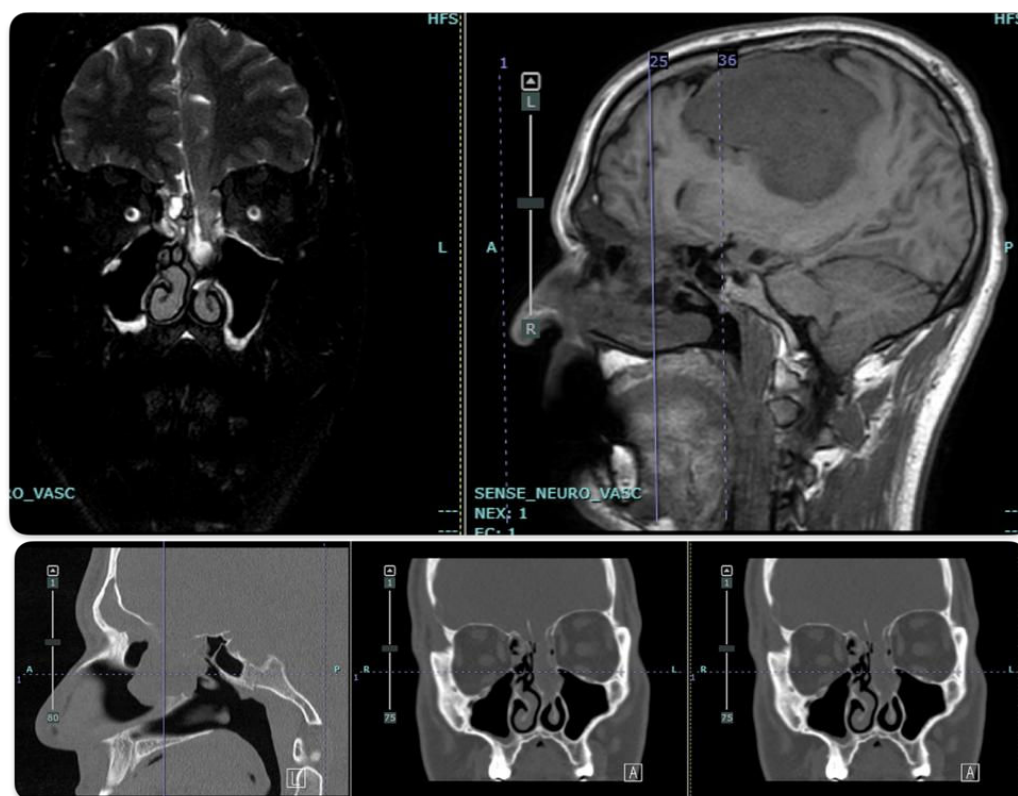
Preoperative MRI and CT scans Paranasal Sinuses (Non-Contrast). MRI (T2 Coronal & T1 Sagittal): Findings of a well-defined encephalocele extending from the left gyrus rectus through a bony defect in the left cribriform plate into the superior nasal cavity.
